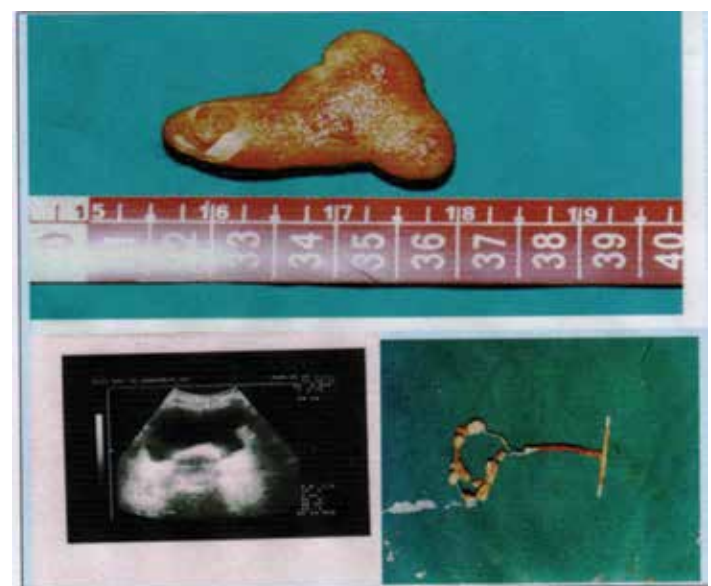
T-Shaped stone (top), a high-echoic mass in the bladder ultrasound (bottom left) and cooper-T intrauterine device (bottom right)
